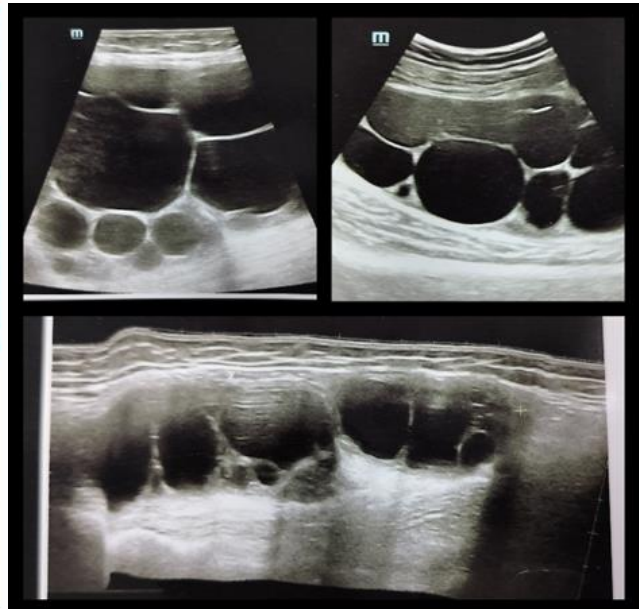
Ultrasonography of right thigh showed a large oval shaped hypoechoic lesion of size 14.8x8.3x4.5 cm with multiple thin walled, variable sized clear cysts in intramuscular plane
